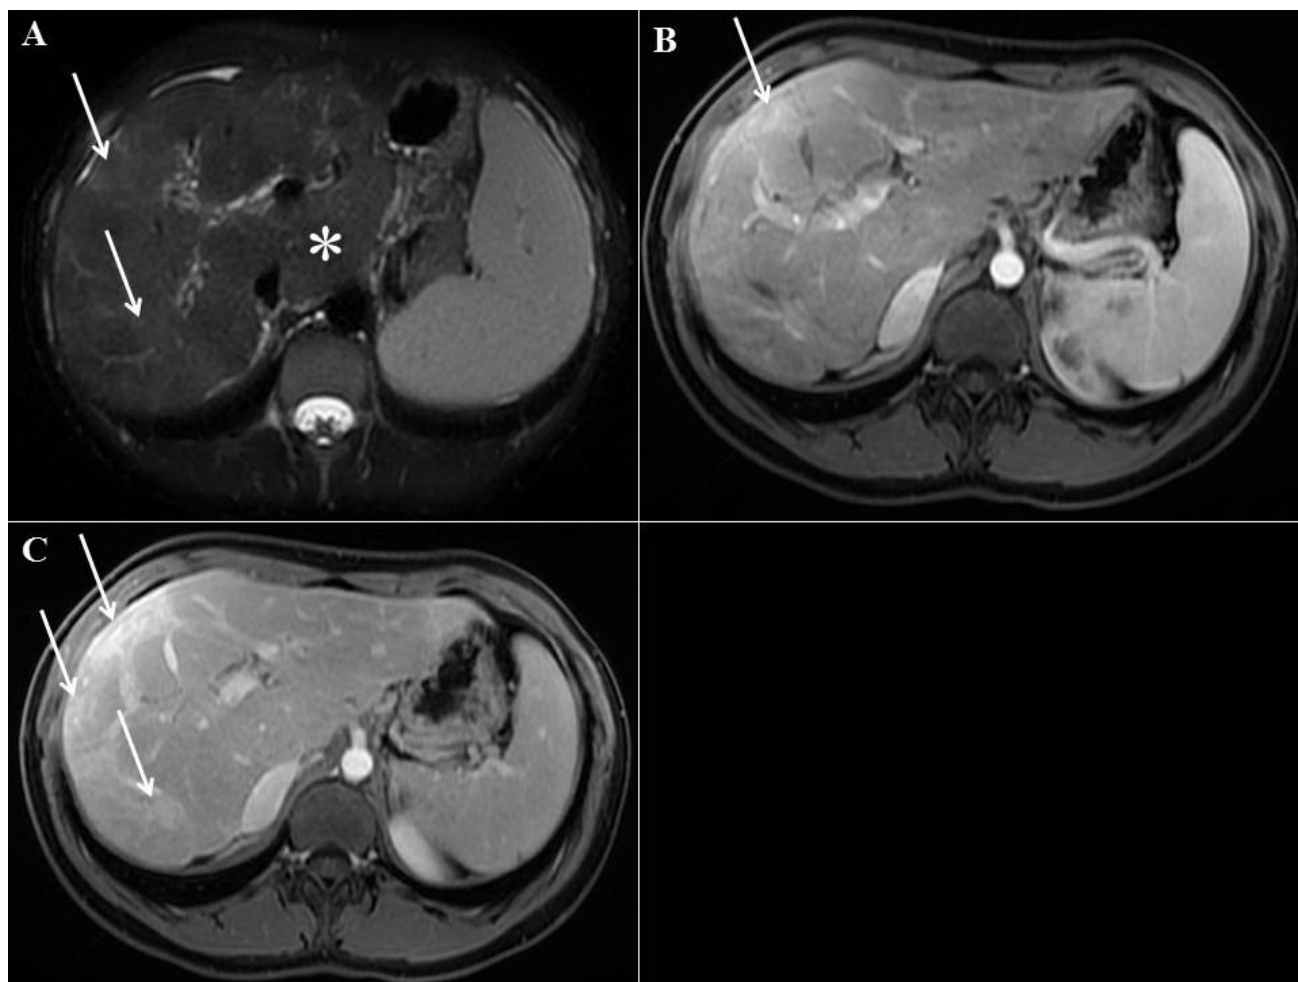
Primary sclerosing cholangitis in 44-year old man. (A) An axial T2-weighted image displays hyperintense areas in peripheral, atrophic regions within the right liver lobe, correlating with sites of parenchymal inflammation and increased water content (*solid arrows*). Additionally, observe the enlarged caudate lobe (*asterisks*). Axial T1-weighted image from the same patient, acquired after intravenous administration of gadolinium chelates during arterial (B) and portal-venous phase (C), depicts increased enhancement of peripheral liver areas, indicative of intrahepatic perfusion abnormalities (*solid arrows*).
